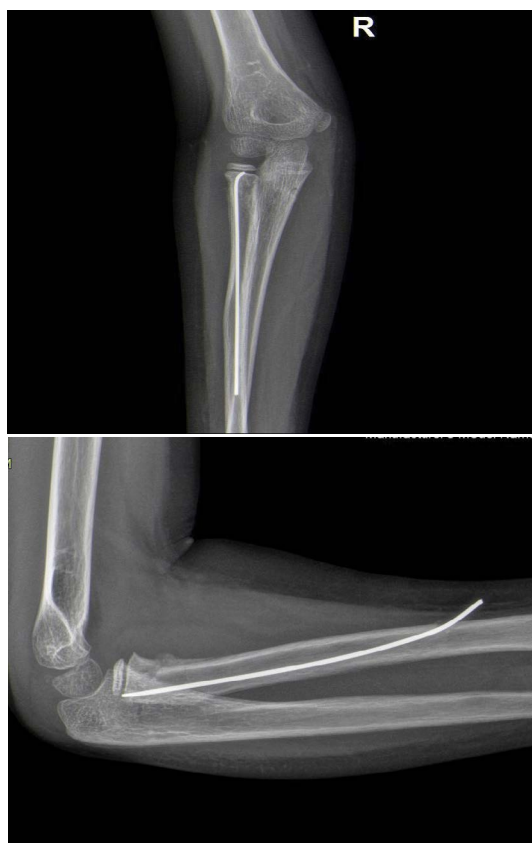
Follow-up antero-posterior and lateral radiographs.
